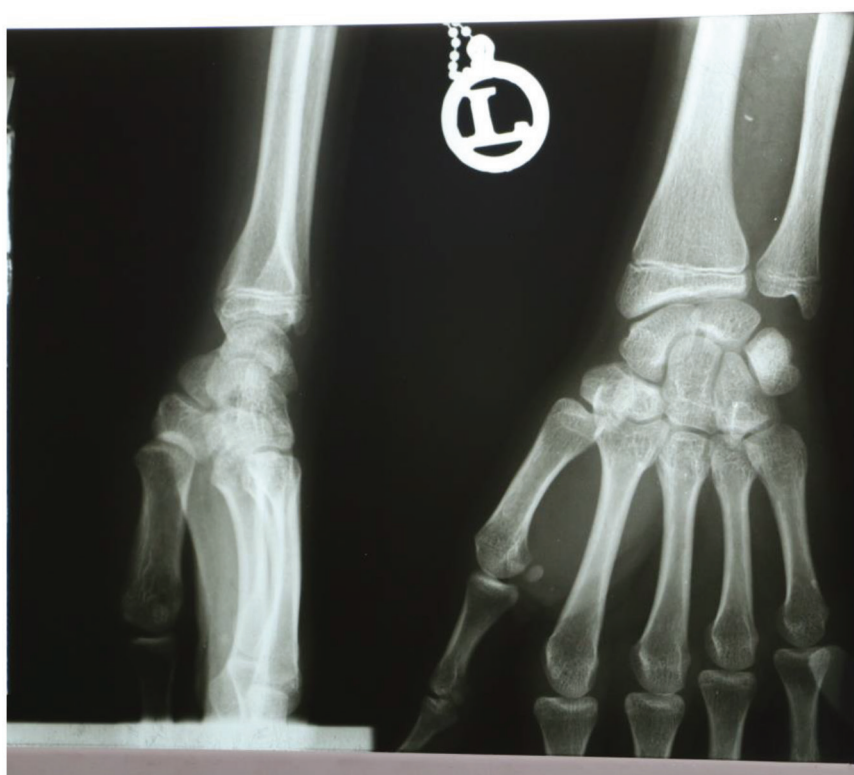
Post-operative anteroposterior and lateral radiographs of the wrist (Normal radiographic views).
